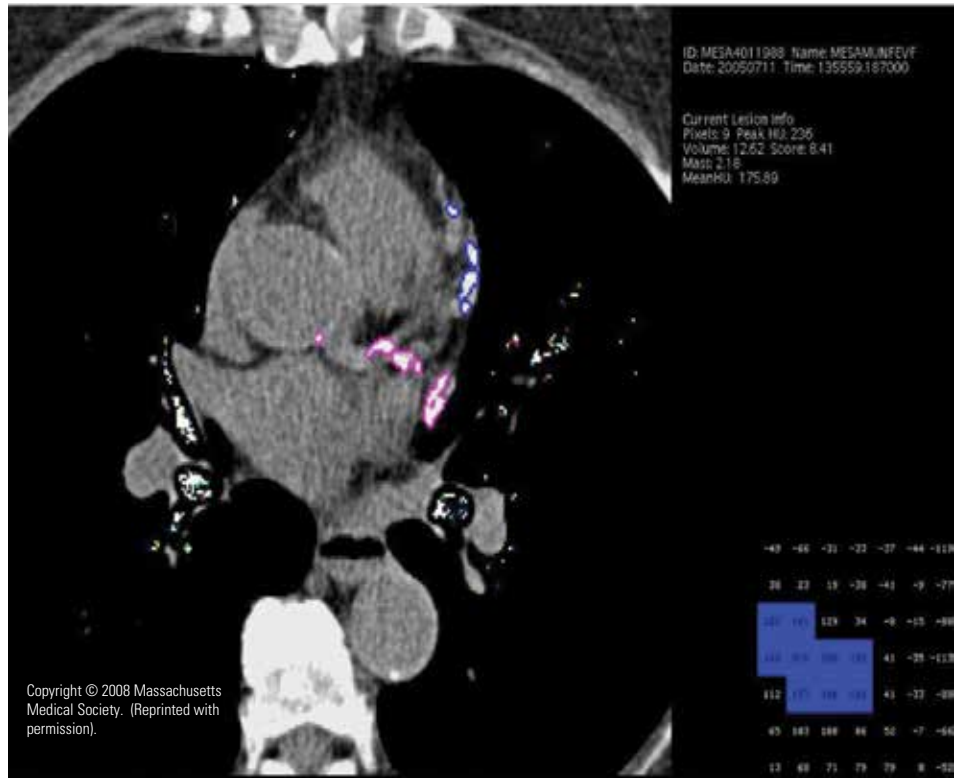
This example of coronary calcium scoring from cardiac CT shows significant calcification of the left main, left circumflex, and left anterior descending arteries.
